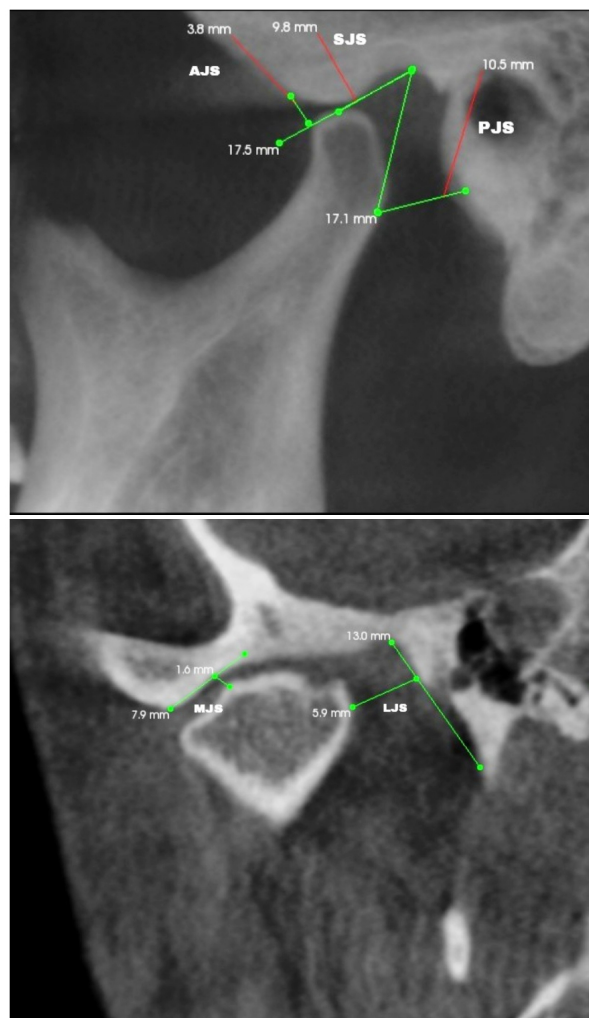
Measurement of AJS, SJS, PJS, LJS, and MJS in the coronal plane of CBCT images.
